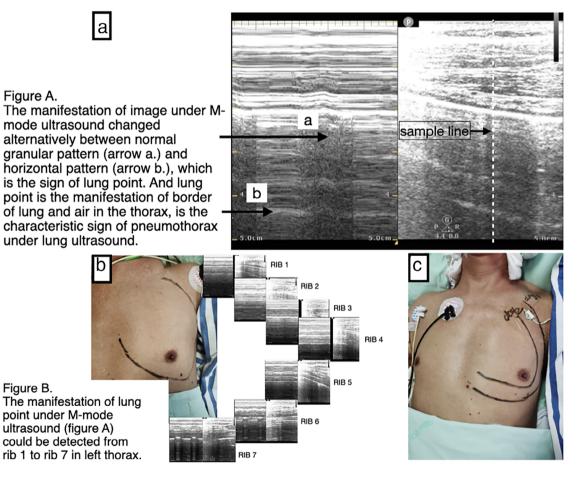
Lung ultrasound revealed the presence of a left pneumothorax. (a) In the time-motion mode of lung point sign, we could see the manifestation of image changed alternately between normal granular pattern (arrow a.) and horizontal pattern (arrow b.) at the defined location according to the respiratory cycle, which is a characteristic sign of pneumothorax. (b) Manifestation of lung point sign under M-mode was detected from the left first to seventh ribs. (c) Scope of left pneumothorax was diminished under monitoring with lung ultrasound. Video of the lung point sign from the first to the seventh ribs was also acquired. (see Appendix S1)
